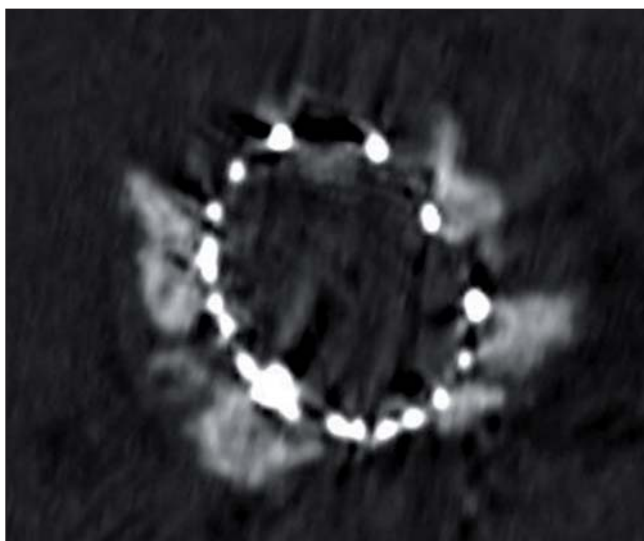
CT scan (cross-section) of Sapien valve implanted in massively calcified bicuspid aortic valve. The mass of calcium pushed aside, but the prosthesis is well aligned.
